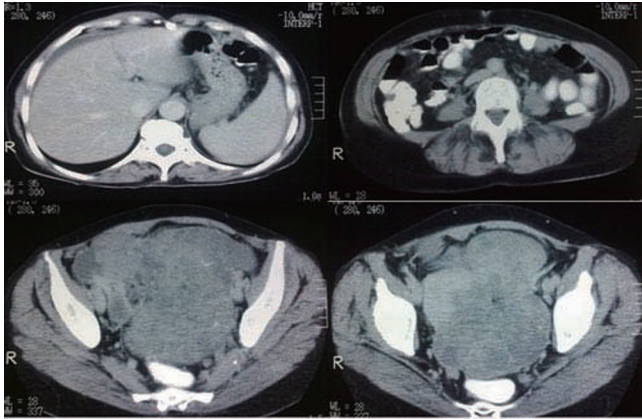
Axial CT images of the left ovarian immature teratoma and perihepatic fluid before the first operation.
